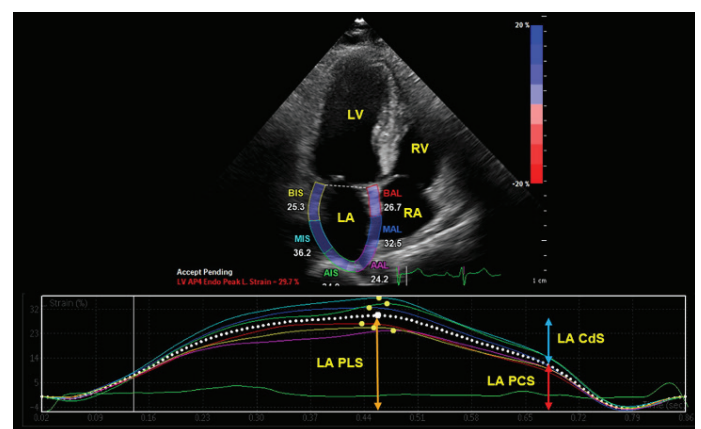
Left atrial strain imaging with two dimensional speckle tracking echocardiography from apical four chamber view of a study patient. Yellow arrow shows peak longitudinal strain (PLS), red arrow shows peak contraction strain (PCS), blue arrow shows conduit strain (CdS).
